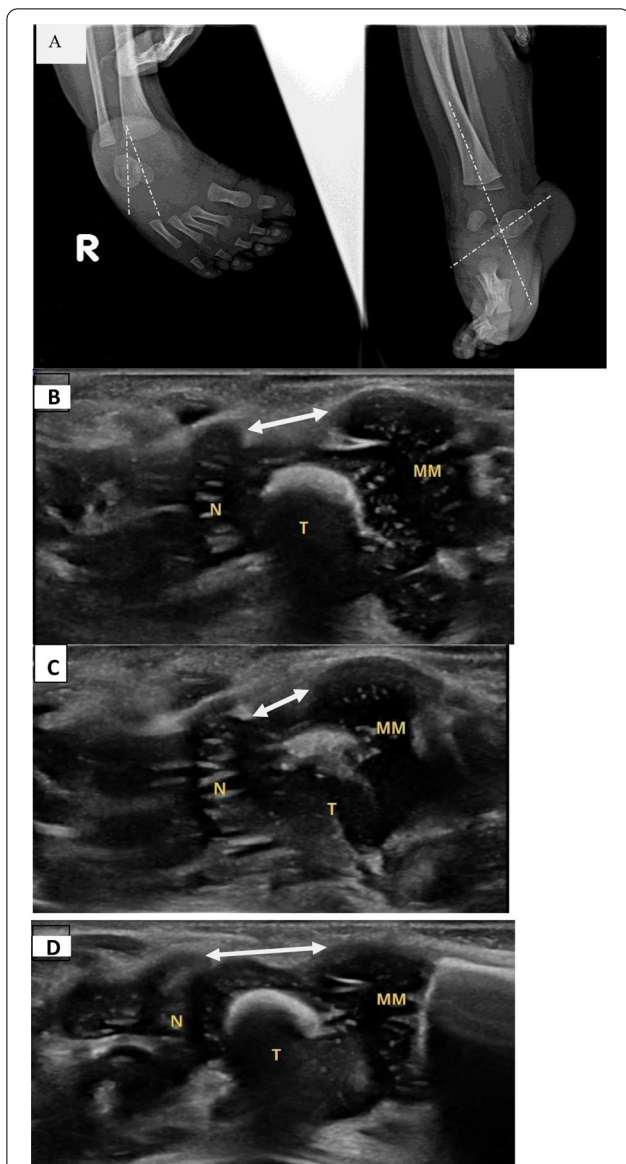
A Plain X-ray foot for a 19-day-old male baby, diagnosed as right club foot, showing increased tibio-calcaneal angle measuring 100 degrees (in the lateral view, image to the right) and decreased talocalcaneal angle measuring 8.5 degrees (in the AP view, image to the left). B–D Ultrasound examination of the same patient showing: B MMN distance (the distance between the medial malleolus and the navicular) in neutral position (less than normal value). C MMN distance in dorsiflexion position (less than neutral). D MMN in plantar flexion (more than neutral)
